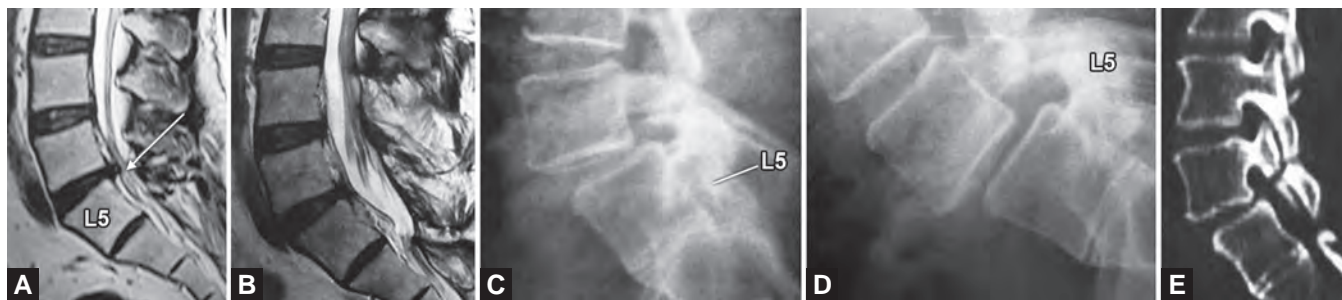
Retrolisthesis at a higher level is often seen with anterolisthesis at lower level. In this patient L4-5 symptomatic anterolisthesis is accompanied by asymptomatic L1-2 retrolisthesis (lateral radiograph, MRI and CT)
